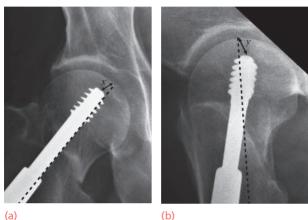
Risk of screw cut-out The tip-apex distance is a measure that estimates the risk of screw cut-out from the femoral head. (a,b) It is the sum of the measured distances (after adjustment for magnification on the X-ray) from the tip of the screw to the apex of the femoral head – on both the AP (x) and lateral views (y). The risk of cut-out is low if the sum is less than 25 mm.
